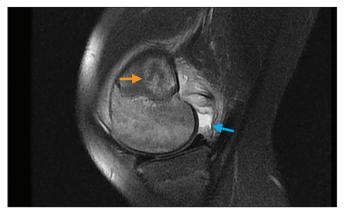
Coronal T2-weighted magnetic resonance image of the right knee showing a  $2.1 \times 1.5 \times 2.9$ -cm bony lesion on the medial femur (orange arrow). Additionally, the magnetic resonance image revealed a partial medial collateral ligament rupture and effusion (blue arrows).
